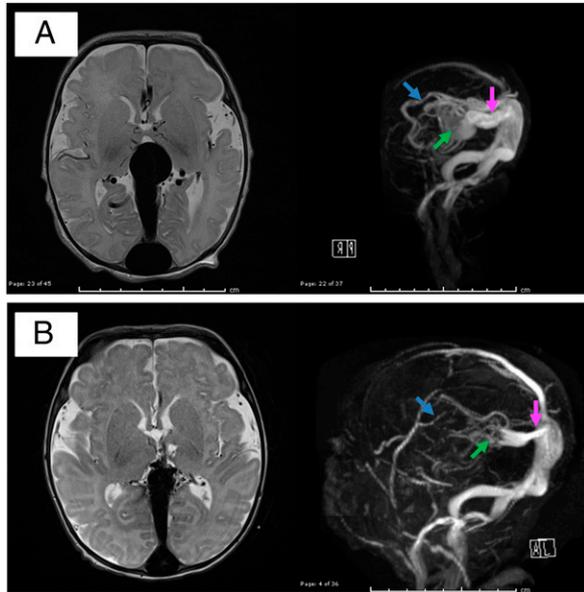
Postnatal magnetic resonance imaging (MRI) scans before and after embolization. Axial T2-weighted MRI scans showing vein of Galen malformation (VOGM) with corresponding 3D venography showing multiple feeding arteries (blue arrow), dilated median prosencephalic vein (green arrow) and prominent draining veins (pink arrow). A. Day 0 after birth before intervention. B. Day 43 after birth after 3 embolization procedures. Significant interval decrease of the arteriovenous shunt.
